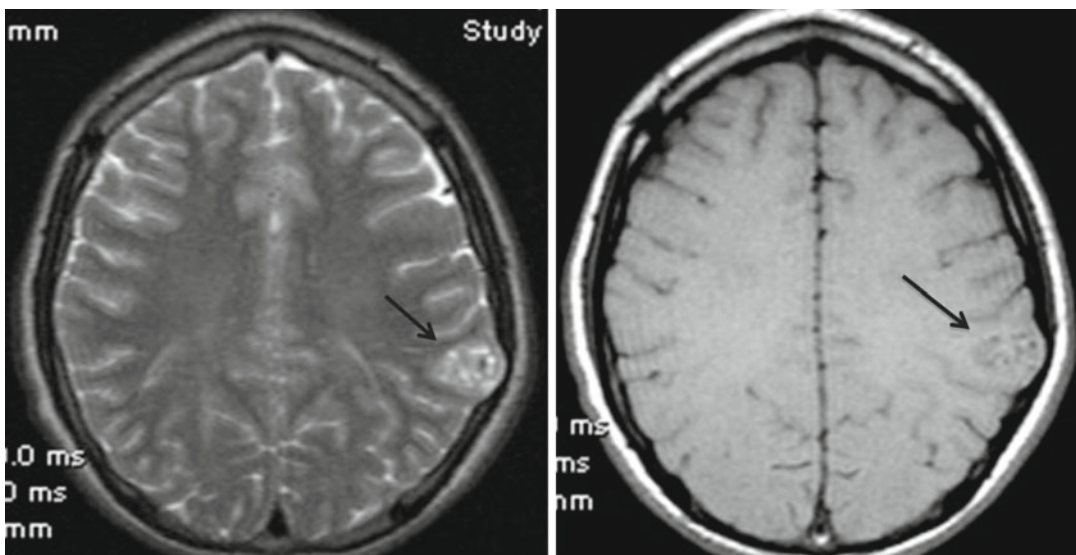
T2-(left) and T1-(right) weighted MRI images showing epileptogenic lesion (ganglioglioma) in left posterior parietal lobe as indicated by the arrows
